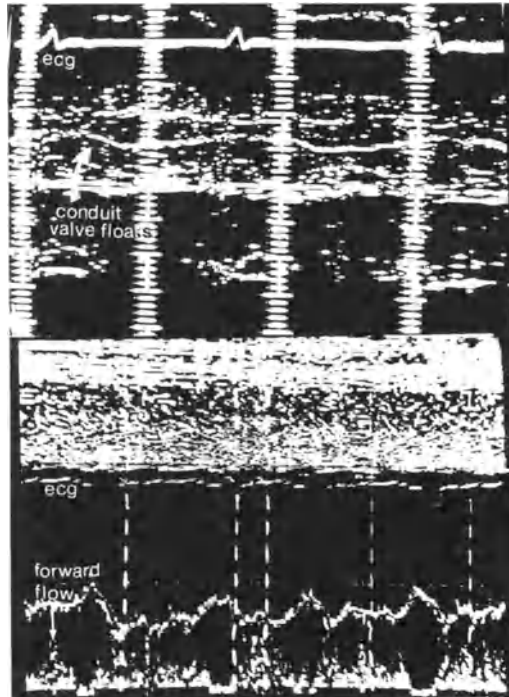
M-mode echo of conduit valve motion (above) and Doppler recording of flow pattern in the pulmonary artery after an atriopulmonary connection. The conduit valve floats more or less open and there is forward flow into the pulmonary artery throughout the cardiac cycle
